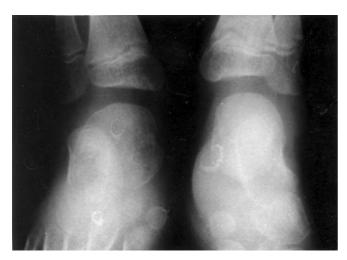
AP radiograph of the ankles showing ball-and-socket type joints
